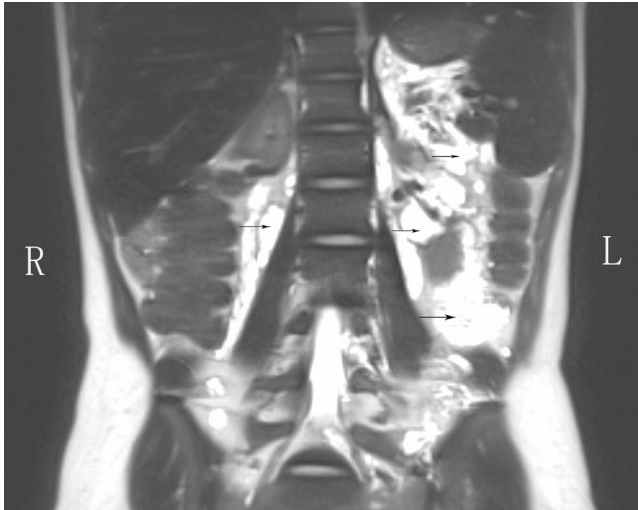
Coronal abdominal T2-weighted magnetic resonance image showing multiple retroperitoneal macrocystic lesions (*arrows*). This feature indicated possible lymphatic malformation, most probably the generalized lymphatic anomaly (GLA) that is a subtype of the lymphatic malformation.
